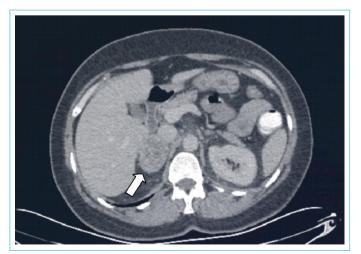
Right adrenal mass in emergency department CT scan (White arrow).
